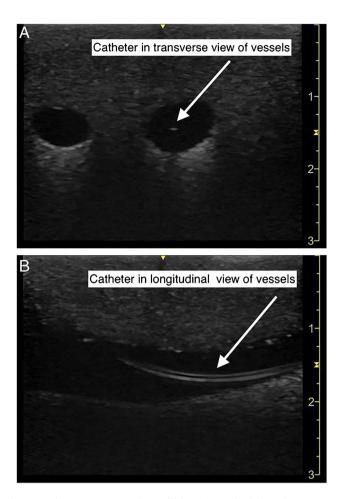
Vascular catheters by ultrasound. A Transverse view of blood vessel with catheter seen in vessel on the right; B longitudinal view of blood vessel with catheter seen
